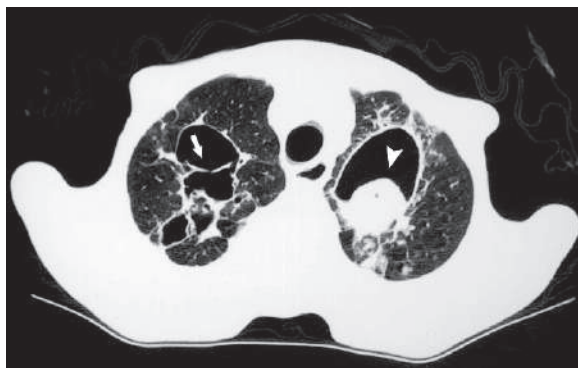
Axial lung window HRCT in a patient with TB shows apical left mycetoma with a halo sign (arrowhead) and marked bronchiectasis in the right lung (arrow)
